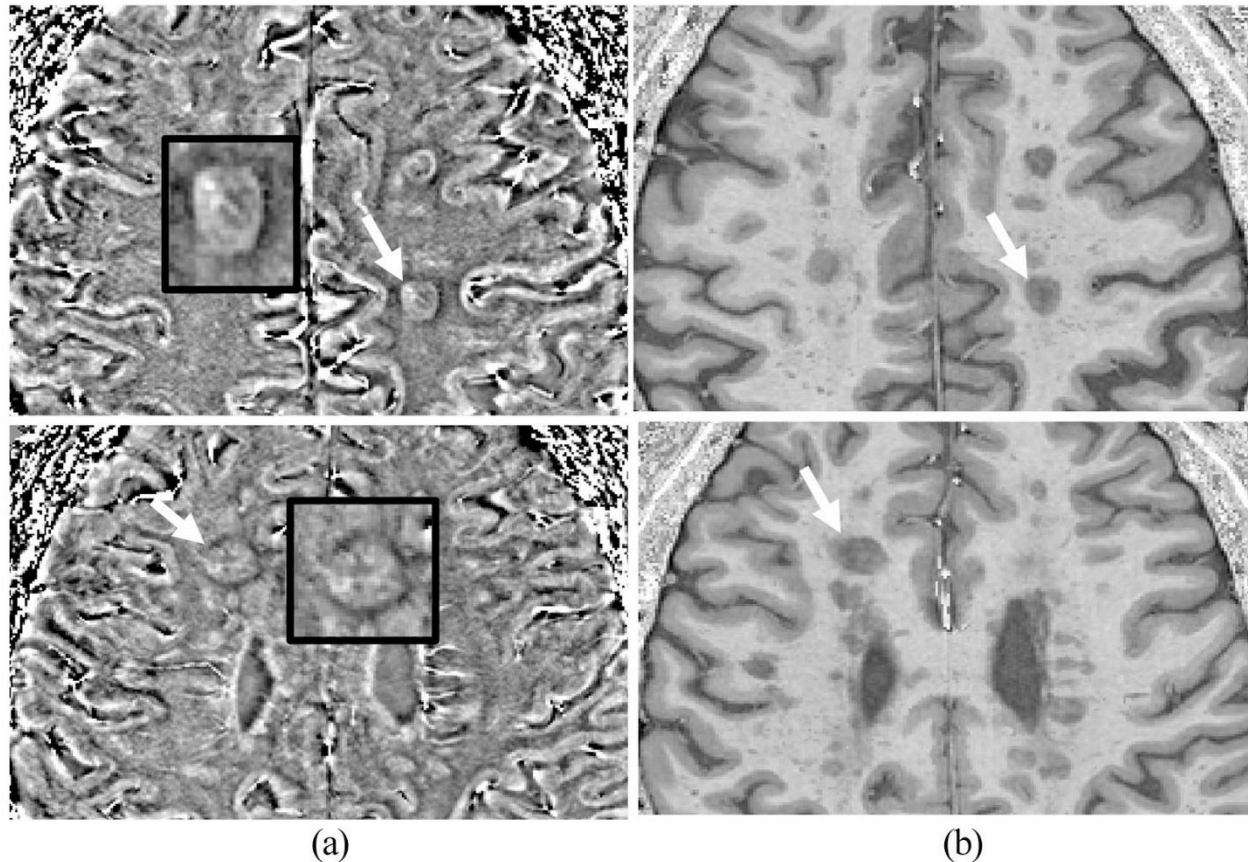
(A) Typical appearance of two lesions with rims on SWI-filtered phase image corresponding with (B) T1-weighted (MPRAGE). Enlarged images of the lesions indicated using white arrows from different patients are shown in the black box with the characteristic hypointense rim surrounding most of the lesion.
